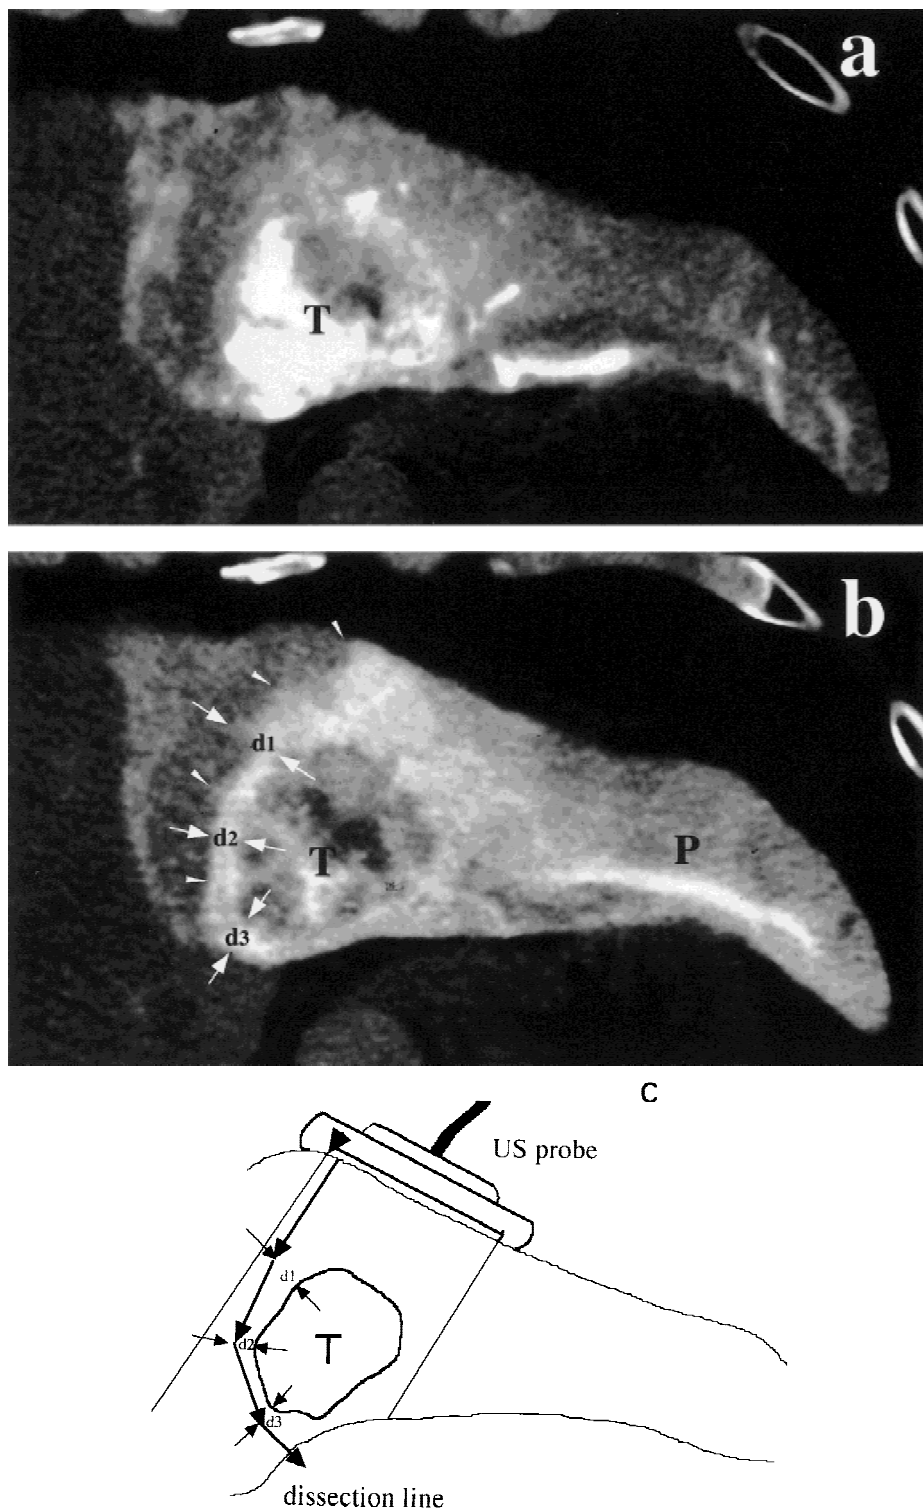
Determination of hepatic resection line using CTHA and ultrasonography. a: Early-phase CTHA. Angiography was performed by injecting the contrast medium into the left hepatic artery. T, tumor. b: Late-phase CTHA. Arrowheads, borderline of tumor blood drainage area; P, portal vein; d1, d2, d3: the distance between tumor and the blood drainage area of the tumor, i.e., the width of the sufficient surgical margin. c: Intraoperative ultrasonography. The dissection line was determined by ultrasonography, taking the width of the surgical margin (d1, d2, d3) and easiness of hepatectomy into account.
